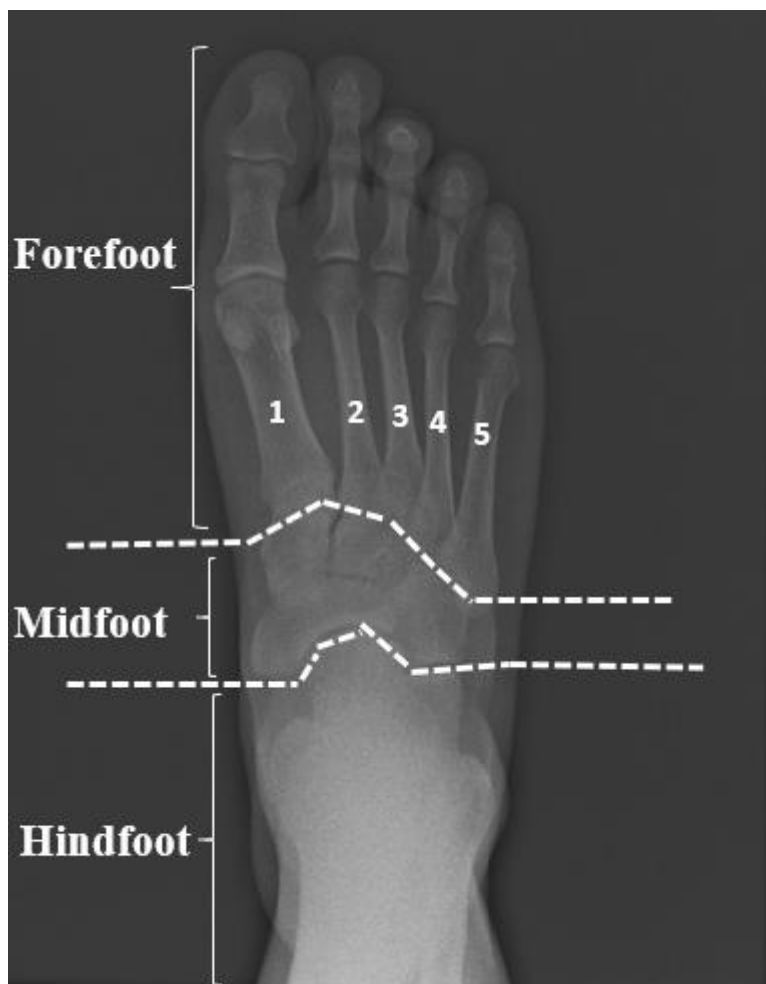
An X-ray photograph (anteroposterior view) of the right foot showing the three main divisions of the foot: forefoot, midfoot and hindfoot. 1= First metatarsal bone, 2= Second metatarsal bone, 3= Third metatarsal bone, 4= Forth metatarsal bone, 5= Fifth metatarsal bone. This is the researcher's own X-ray photograph.
